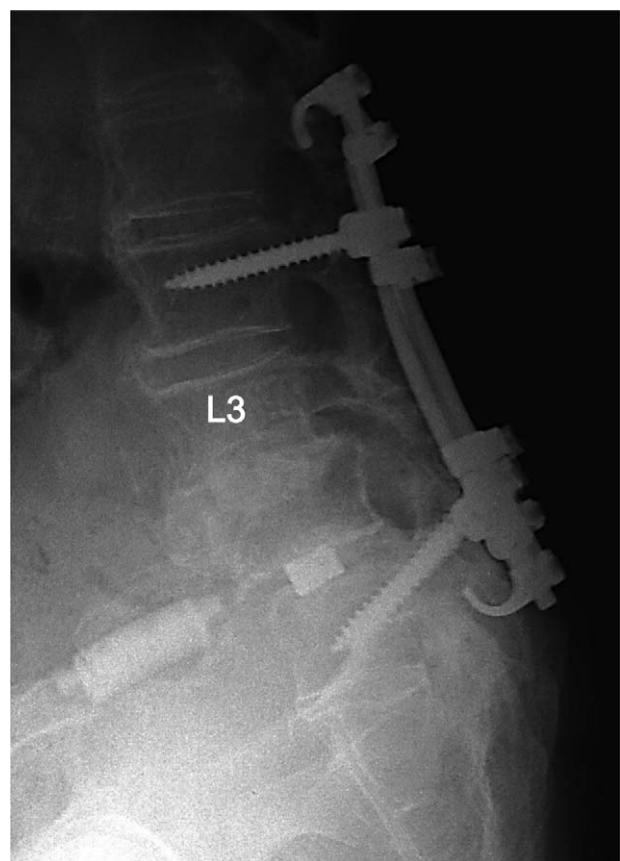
Lateral plain radiograph of the lumbar spine taken 5.5 years after a second revision surgery.
